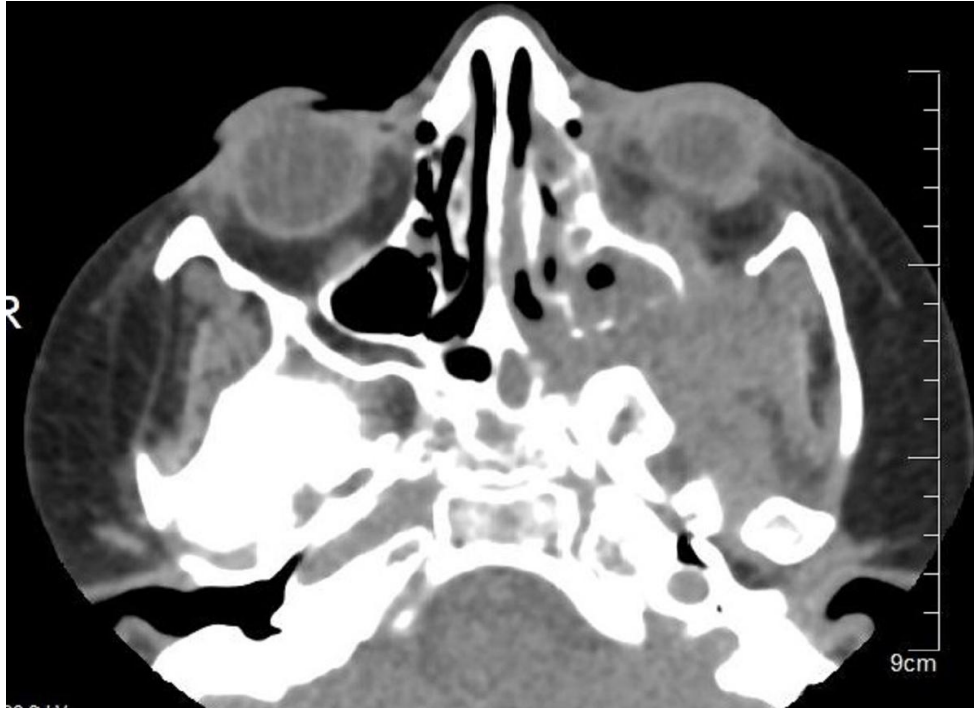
CT scan image shows a soft tissue mass in the left infratemporal fossa extending to pterygopalatine fossa via pterygomaxillaryfissure, sphenopalatine foramen and to left orbit
